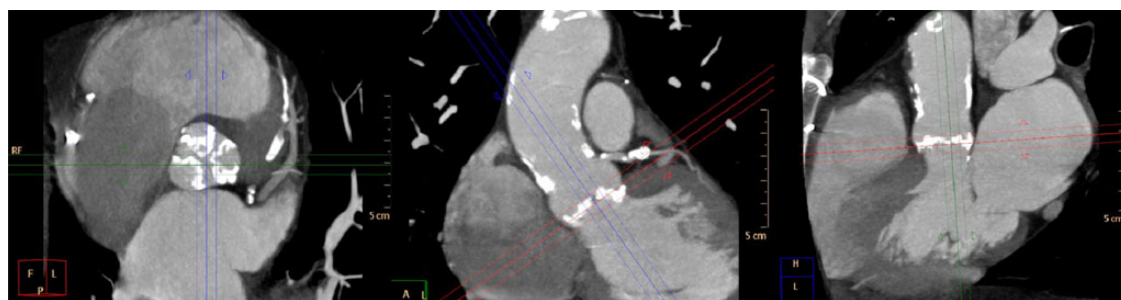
Multi-slice computed tomography assessing aortic valve anatomy and calcification.
